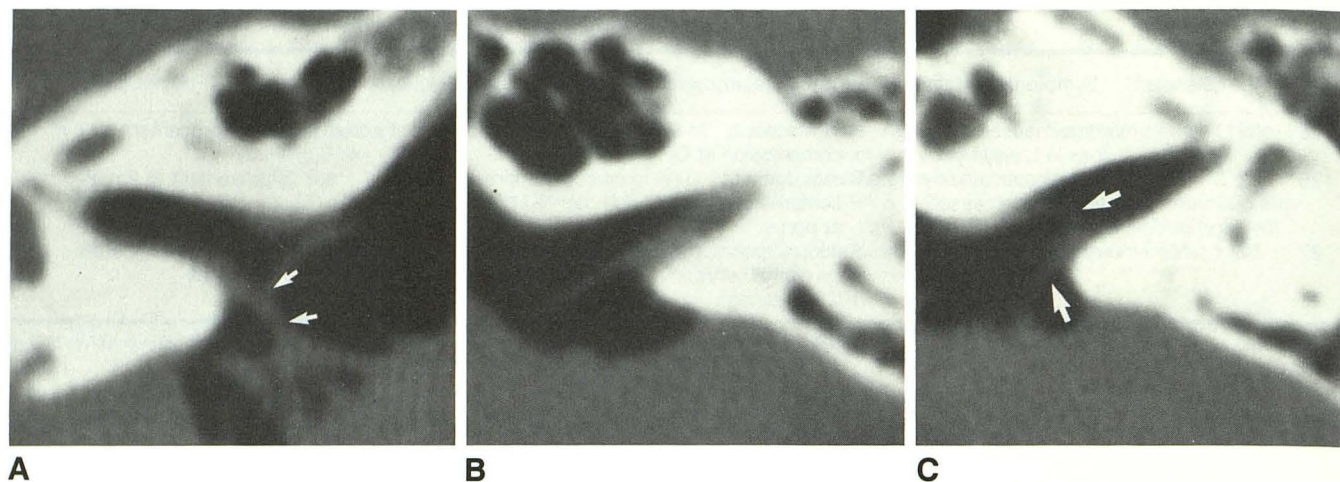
Case 19: Bilateral air CT cisternography.
